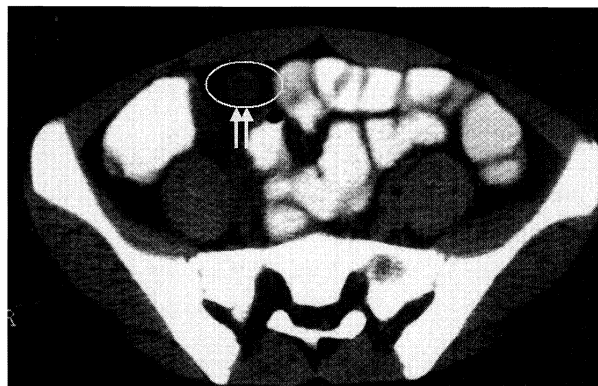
CT scan in patient (36years old, male, WBC: 12500, CRP:4.7) with acute appendicitis. CT scan at the cecal level shows an enlarged appendix that filled with neither air nor contrast material.
